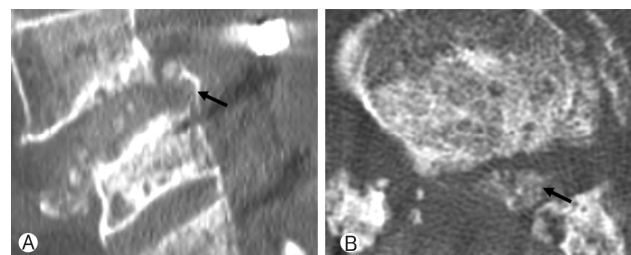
78-year-old male underwent L3-4-5 posterior lumbar interbody fusion with rhBMP-2 (Bio-BMP2) applied to the top and bottom surfaces of the interbody cage. At 12 months after operation, postoperative CT scan showing that ectopic bone was grown to the left side in the spinal canal at L4-5 level on Sagittal (A) and Axial (B) cuts. There was no clinical symptom correlated with. Rh-BMP2; recombinant human bone morphogenetic protein-2.
